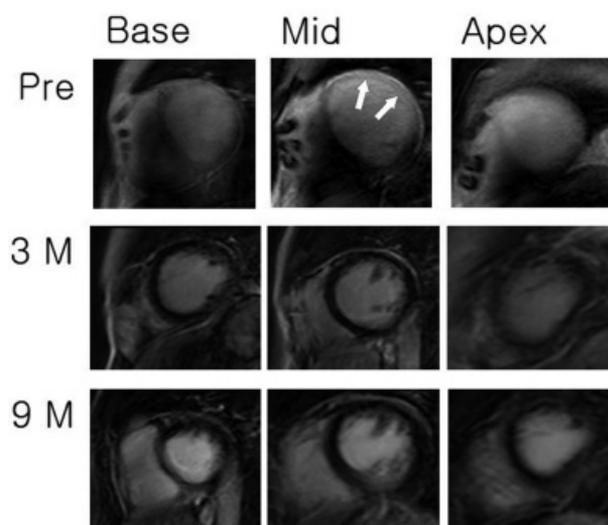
Cardiac magnetic resonance imaging with gadolinium contrast; top row: infarction seen as a bright signal (arrows) at the left ventricular anterior and lateral walls, extending from base to apex, before stem cell transplant. Left ventricular ejection fraction was 13.2% with end-diastolic volume of 296 mL; middle row: 3 months after stem cell transplant, there was no myocardial scar and ejection fraction was 20% with end-diastolic volume of 268 mL; bottom row: after 9 months, there was no myocardial scar and ejection fraction increased to 36.5% with end-diastolic volume of 175 mL.
